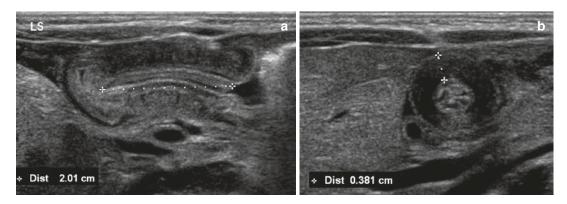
Pyloric stenosis. (a) Longitudinal and (b) transverse ultrasound images of the pylorus show a thickened elongated pyloric muscle with channel
